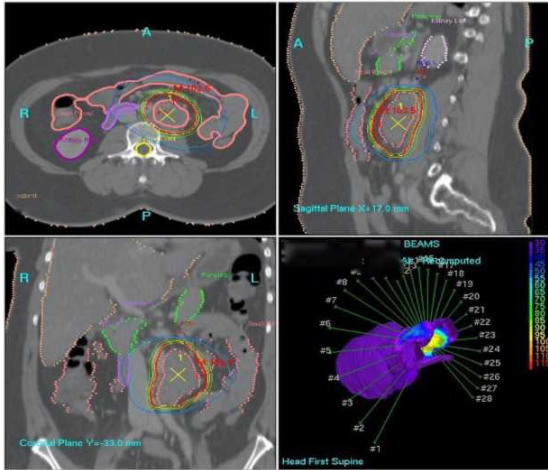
CT-topometric planning of stereotaxic irradiation of para-aortic lymph Nodes.
